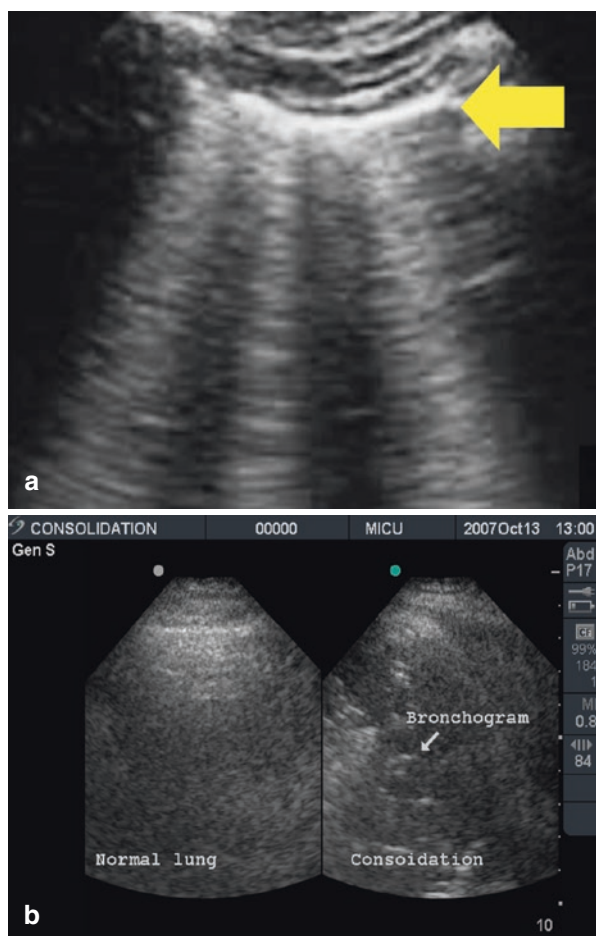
Lung ultrasound for evaluation of lung contusion. The sonographic patterns indicative of lung contusion include “alveolar interstitial syndrome (AIS)” which is identified by an increase in B-lines with no clinical suspicion of cardiogenic pulmonary edema or the presence of a “peripheral parenchymal lesion (PPL)” defined as observation of C-lines (confluent consolidations or “hepatization”) which are hypoechoic subpleural focal lesions which identify areas of focal lung consolidation. (a) B-lines are vertical densities extending from the pleura (arrow) throughout the entire depth of the scanning field. Three or more B-lines within one lung segment suggest increased interstitial lung water consistent with passive congestion, pulmonary edema, infection, and/or inflammation involving that anatomic area. (b) C-lines are hypoechoic areas of confluent consolidation in the subpleural region which identify areas of focal lung consolidation or lung contusion
